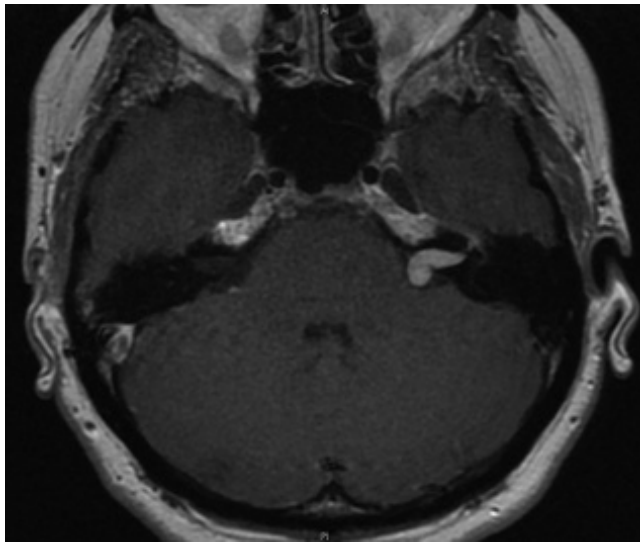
Axial T1 weighted MRI of patient who presented with facial weakness showing contrast enhancing tumour of the IAM/CPA with subtle enhancement of adjacent segment producing ‘labyrinthine tail’.
